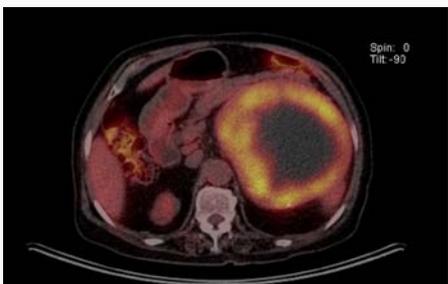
PET showed the accumulation of FDG in the left adrenal tumor and lymph nodes in para-aortic area.
